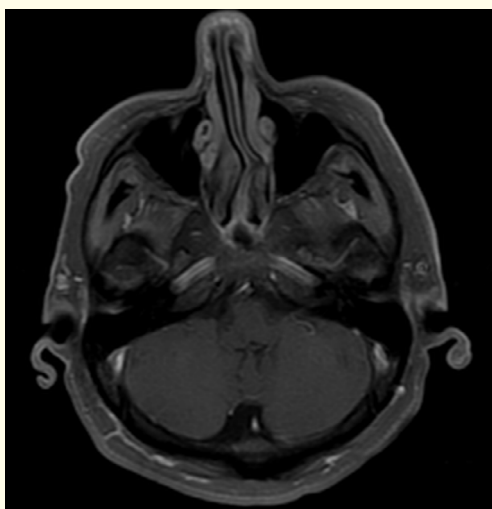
MRI of the skull in an axial at the level of the posterior fossa after the administration of Gadolinium (Gd), the absence of enhancement is demonstrated.
